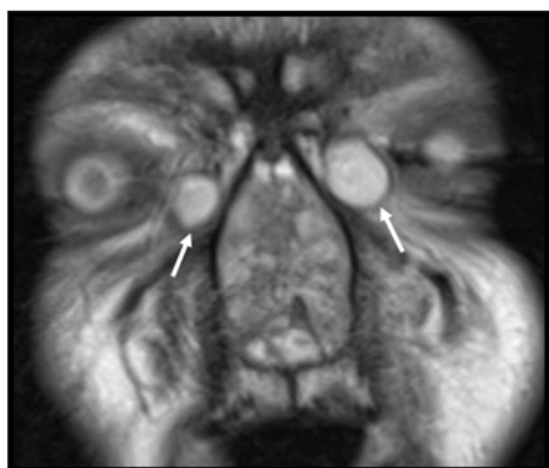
MRI bilateral dilation of the lacrimal sacs (white arrows) due to the compression of both naso lacrimal ducts by a tumor.
